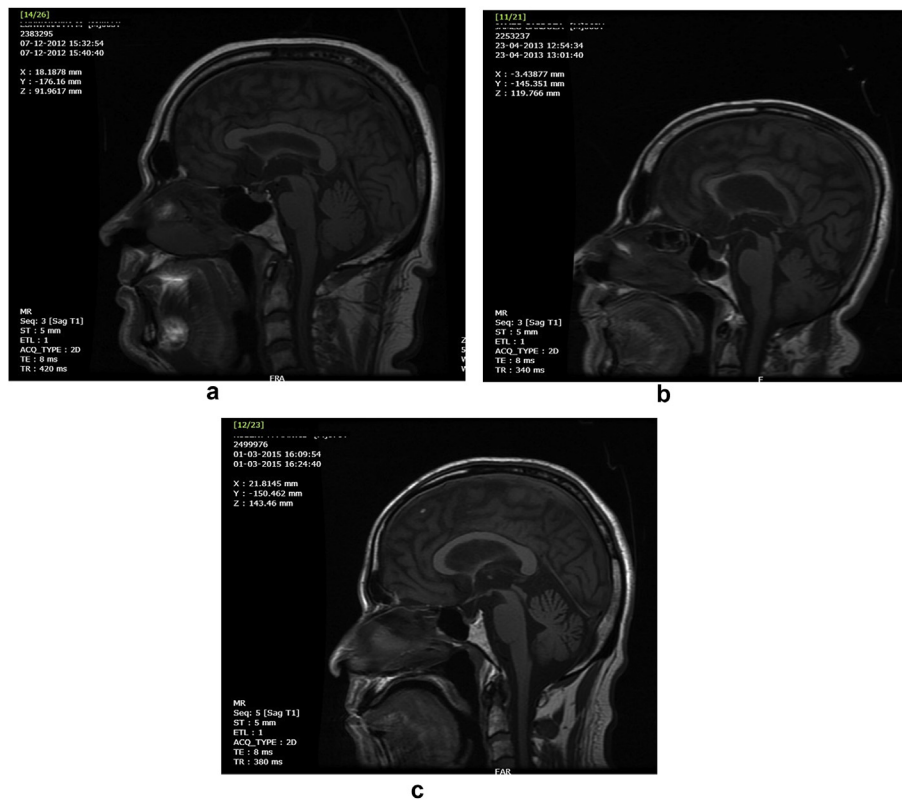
The superior profile of midbrain in midsagittal MR images classified as convex (4a), concave (4b), and flat (4c).
